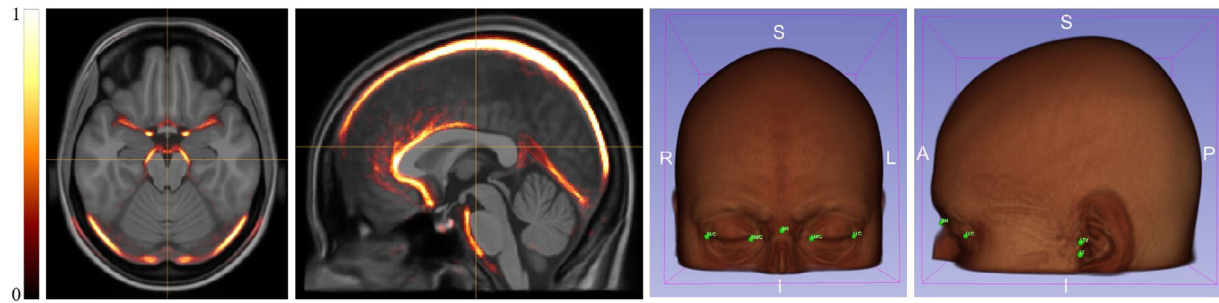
Axial and sagittal views of the MRI template superimposed by the average vessel map, highlighted using the heat colormap, and the 3D volume of head template with average facial landmarks. MRI, magnetic resonance imaging.
